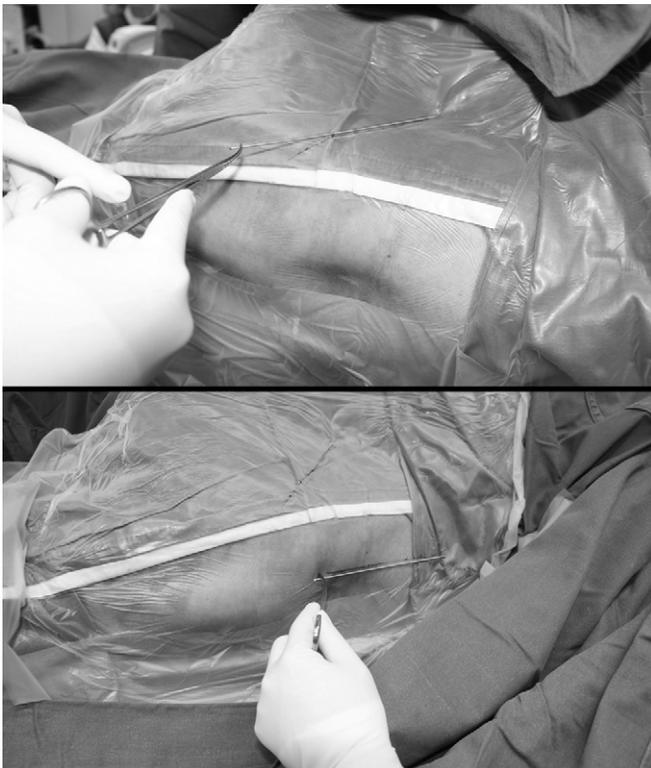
Mark the planned incision site under X-ray control with a K-wire.
